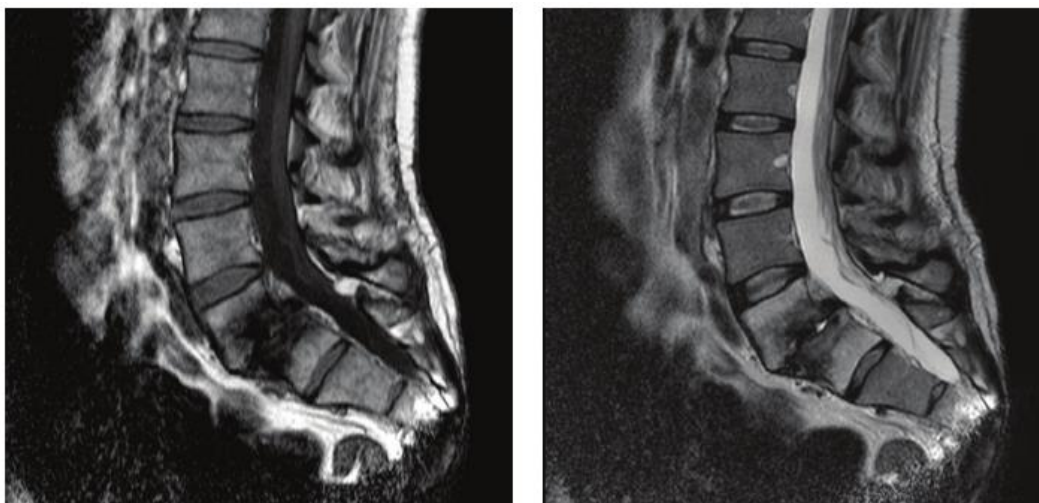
MRI showing an L5/S1 with severe discopathy [Webpage: ResearchGate]
